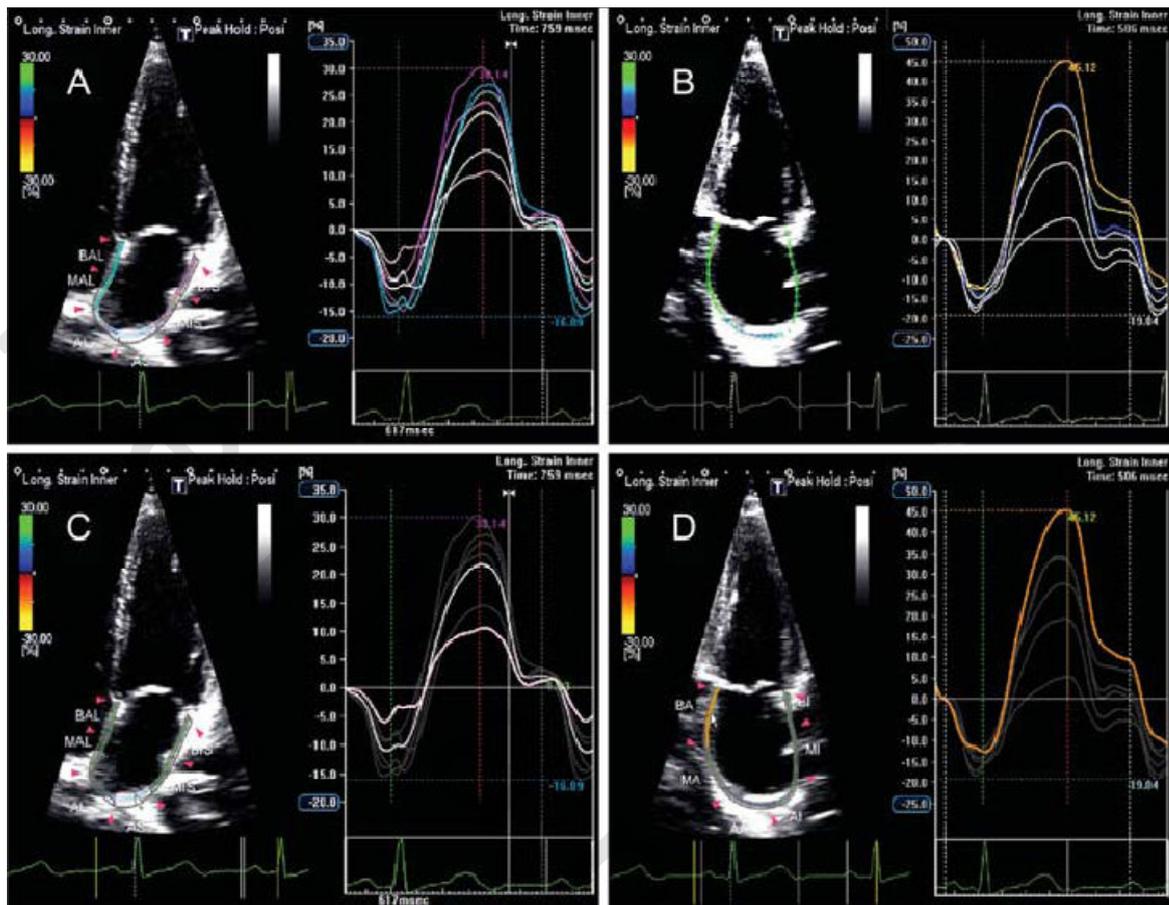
Regional left atrial strain ⁽¹¹⁹⁾. Two-dimensional echocardiography apical four-chamber view (A) and apical two-chamber view (B) showing left atrial longitudinal strain in a normal subject. Longitudinal strain during the reservoir phase in the roof segment (C, pink line) shows lower absolute values when compared with the annular segment of the inferior wall (D, brown line).
